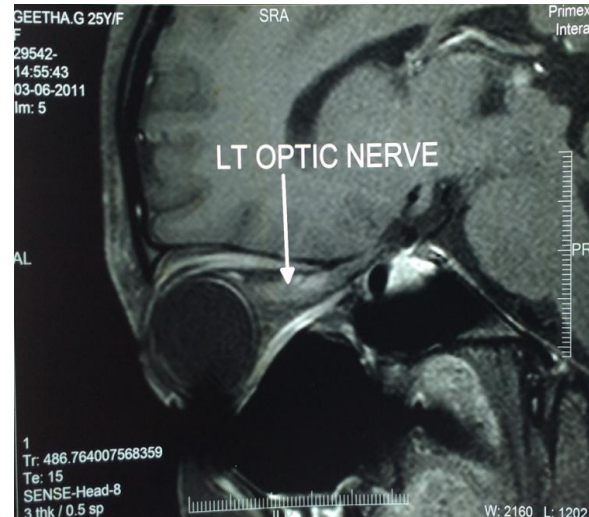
MRI Brain (T1) showing enhanced left optic nerve
